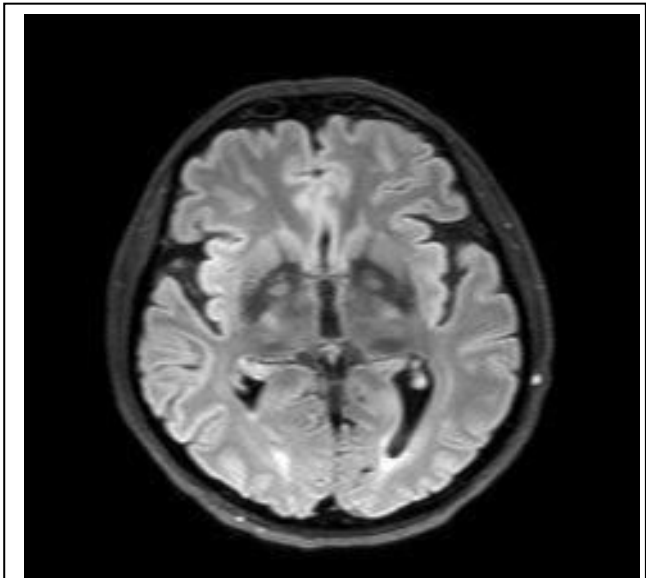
and 1B: Brain MRI axial T2-weighted (1A) and FLAIR (1B) images show a heterogeneous hyperintensity with surrounding hypointensity in the central area of Globus pallidus, known as Eye of the tiger-sign.
